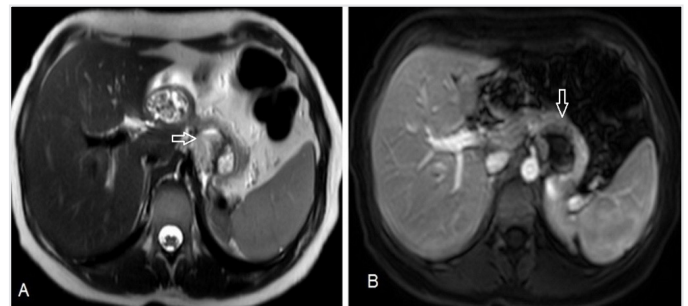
A) Axial T2-weighted image showing regression of the cystic mass (arrow). B) Portal phase contrast-enhanced axial T1-weighted image did not show septal or solid tissue contrast enhancement (arrow)
